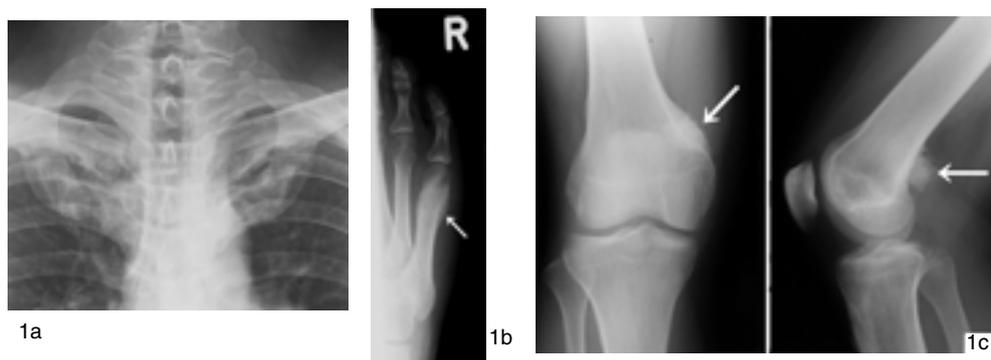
Plain X-ray examination revealed mixture of hyperostosis of sternocostoclavicular region (a), sclerosis (arrow) of the right distal 5th metatarsal bone (b) and tumor-like bony proliferative lesion (arrow) (c) in his right knee medial condyle.
